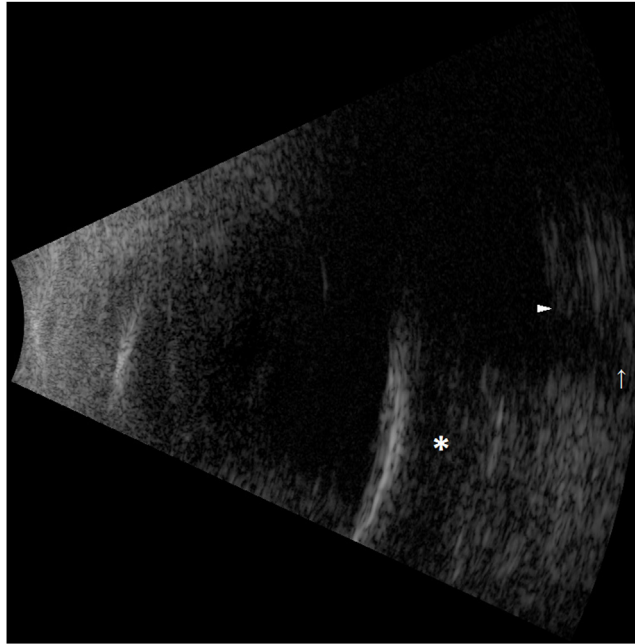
Vertical B-scan ultrasound of the left eye, showing intravitreal blood clot (asterisk) posterior to silicon oil, peripapillary scleral edge (arrow head), and retracted optic nerve (arrow).
